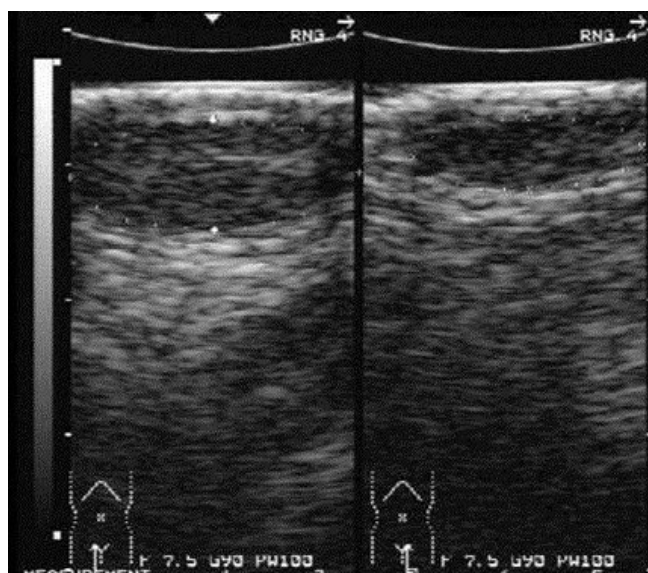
Ultrasonography of the inguinal region
